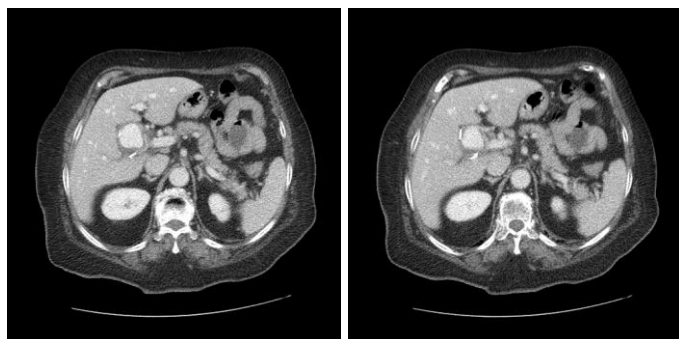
Contrast enhanced computed tomography showing pseudoaneurysm of right hepatic artery
